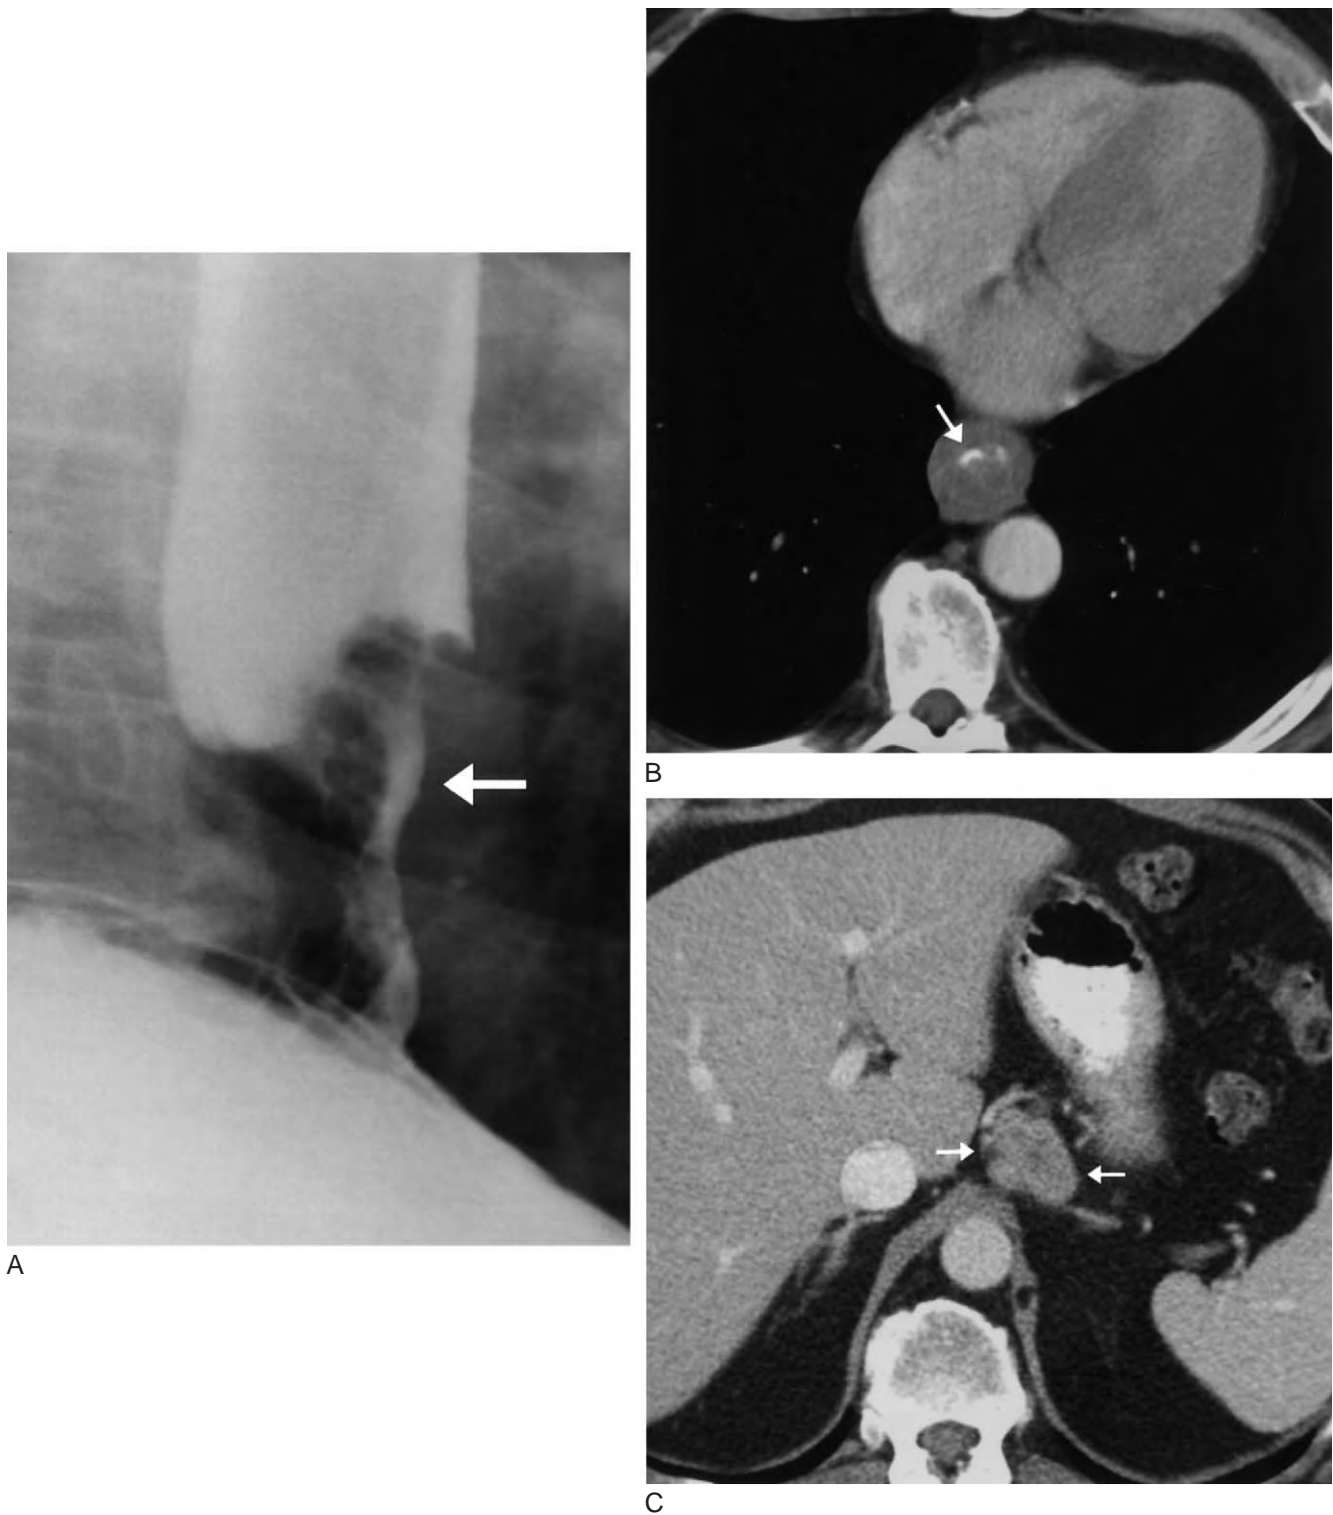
Grade 4 adenocarcinoma of the lower part of the esophagus within an area of Barrett's esophagus in a 65-year-old man. A, An esophagogram shows an abrupt fungating mass with ulceration and asymmetric luminal narrowing (*arrow*). B, An axial CT image shows asymmetric esophageal wall thickening, confirmed by the presence of esophageal luminal contrast (*arrow*) within the eccentrically narrowed lumen. C, Enlarged (2.7 × 4 cm) celiac lymphadenopathy (*arrows*) is seen on this axial CT image. Fine-needle aspiration of these nodes by endoscopic ultrasound confirmed adenocarcinoma metastases, thus making this lesion M1a.
